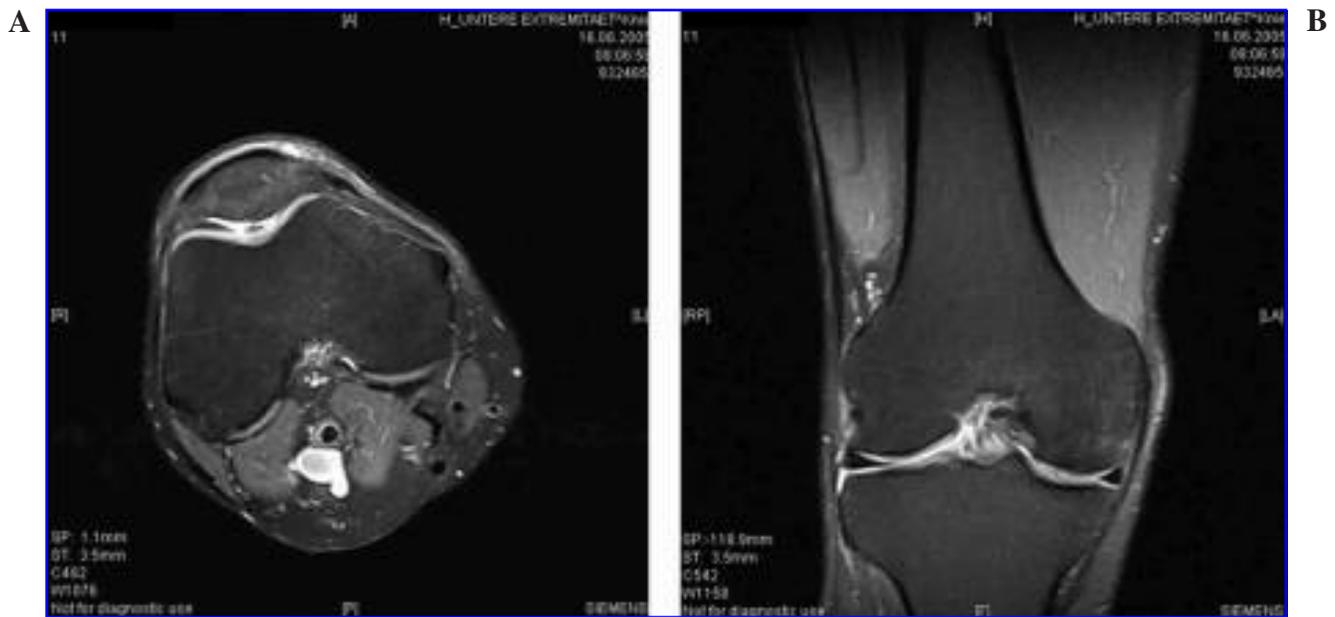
These MRI images, made on June 16, 2005, are a coronary fat-suppressed PD TSE sequence. (A) Axial and (B) frontal images, showing almost complete restitution of the spongiosa edema.
